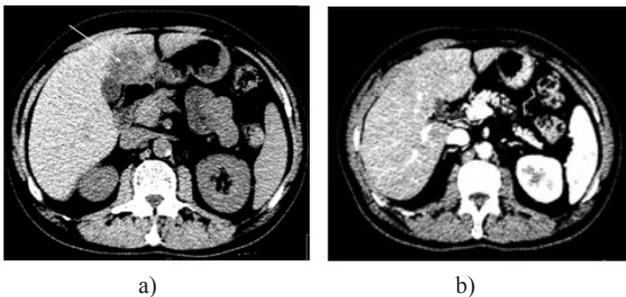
Abdominal CT scans before (a) and after (b) treatment
